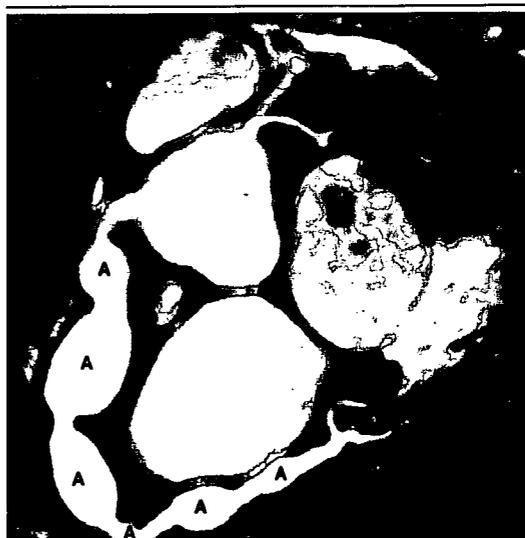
Three-Dimensional Steady-State Free-Precession MRI of the Whole Heart in an 8-Year-Old Boy with Kawasaki Disease and Serial Aneurysms (A) in the Right Coronary Artery.
